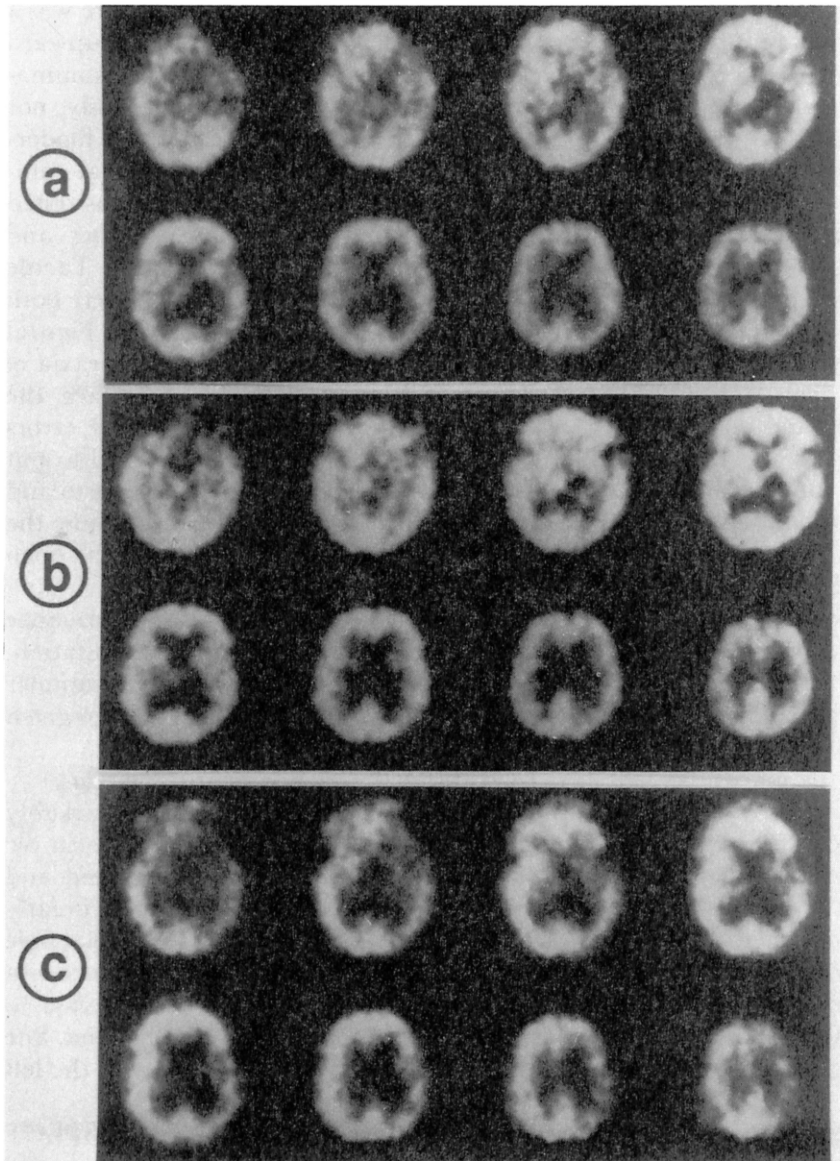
SPECT studies on (a) day 4, showing a marked perfusion deficit in the area of the left thalamus and posterior part of the basal ganglia, as well as a hypoperfusion of the whole cortical mantle of 9% as compared to the right hemisphere, (b) day 19, with increase of the perfusion deficit of the left hemisphere (14%), despite marked clinical improvement, and (c) day 143, with virtually unchanged perfusion in spite of further clinical improvement. The orientation of the SPECT images corresponds to the CT scan in Fig. 1, i.e. the right side of the images corresponds to the left side of the brain.
